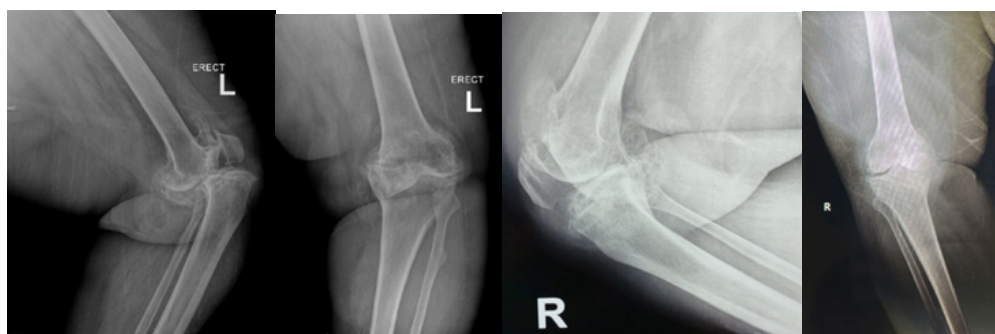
Pre-Operative Anteroposterior and Lateral Knee Radiographs
